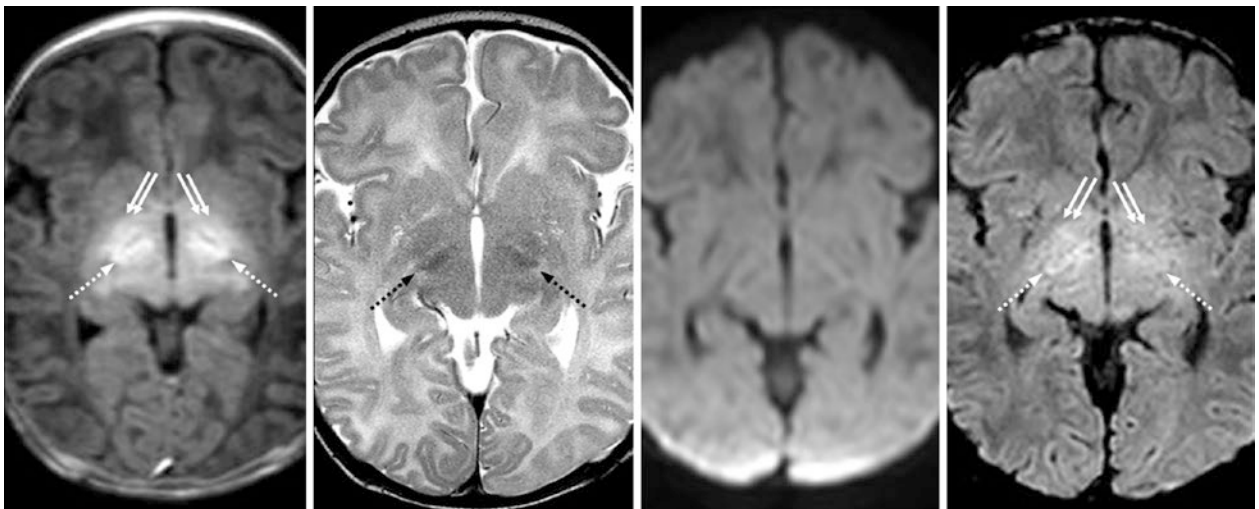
A 15-day-old term neonate with respiratory depression at birth had a normal 3T MRI, which included spoiled GE T1WI (*left*), SE T2WI (*left middle*), DWI (*right middle*), and SWI (*right*). Both the subthalamic nuclei (STN) (*dotted arrows*) and GP (*double arrows*) are
